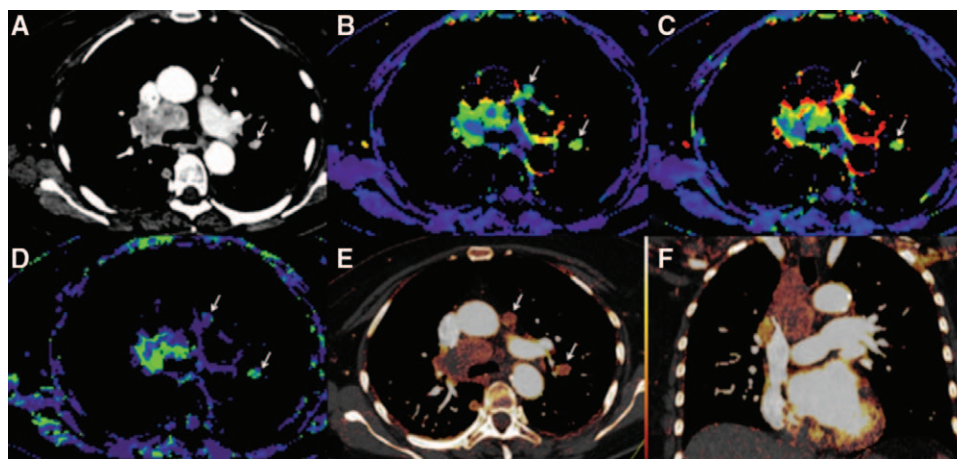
CT images of a 68-year-old patient with a central NSCLC that underwent whole tumor volume dynamic contrast-enhanced CT (A–D) as well as dual-energy CT for tumor staging before TKI therapy. A, One late arterial phase gray scale image 25 seconds after the contrast agent administration. B–D, Color-coded images representing blood volume (B), blood flow (C), and the mean transit time (D) of the contrast agent through the tumor. E and F, The corresponding dual-energy CT images. The blood volume (tissue iodine content) is color coded within the image and correlates with the blood volume from the dynamic series (B). The arrows demonstrate a highly perfused lymph node metastasis as well as a contralateral intrapulmonary metastasis. CT, computed tomography; NSCLC, non-small-cell lung cancer, TKI; tyrosine kinase inhibitor.
